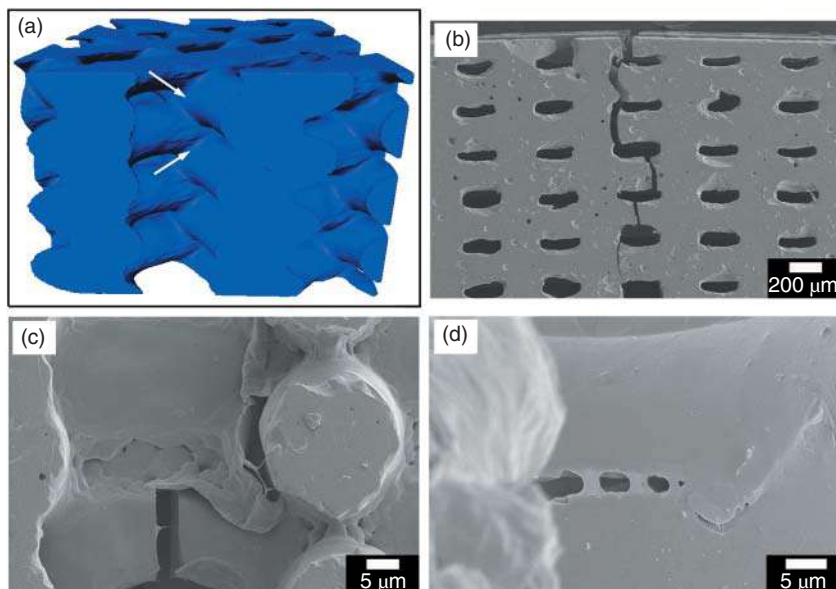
(a) A three-dimensional view of the joining of adjacent glass struts using synchrotron X-ray tomography; (b) crack propagation path in a precracked uncoated glass scaffold; (c) crack propagation path in a precracked PCL-coated glass scaffold; (d) PCL fibril elongation in coated glass scaffold after bending test. Source: Fu et al. [122], Figure 09, p. 07/with permission of John Wiley & Sons, Inc.
